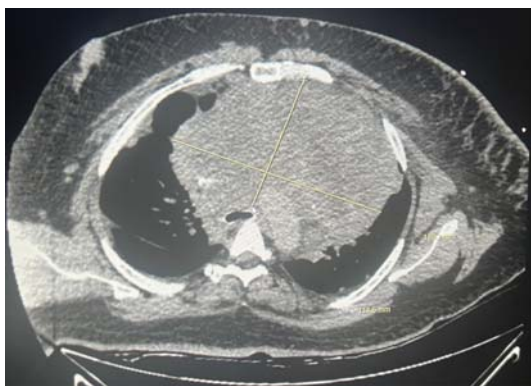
Contrast-enhanced CT (CECT) thorax showing giant anterior mediastinal mass
